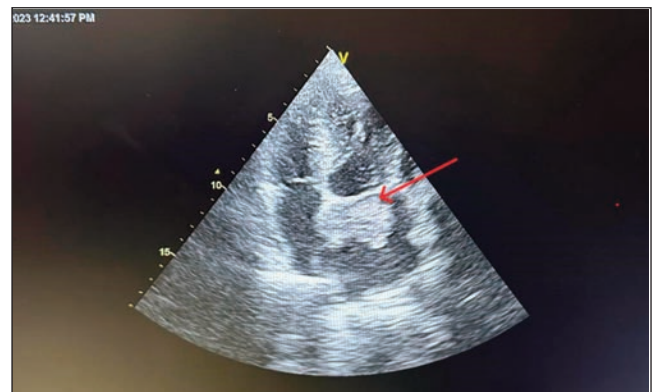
Pre - Op Four chamber Transthoracic Echocardiography showing clear demarcation between the Mitral valve and the Atrial Myxoma.
